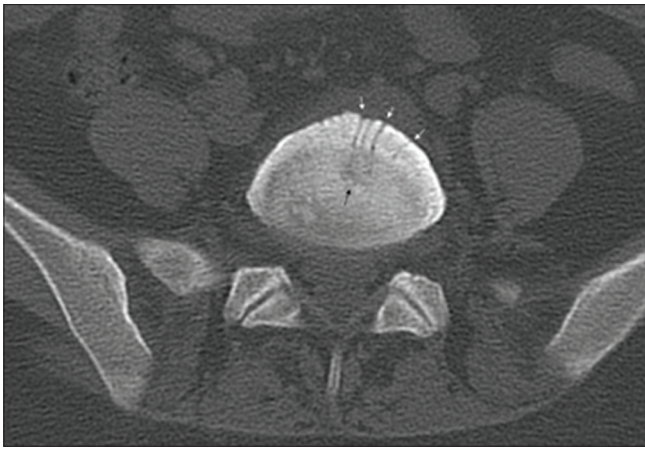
Computed tomography scan axial image of the L5 vertebral body showing (with arrow) multiple grooves
